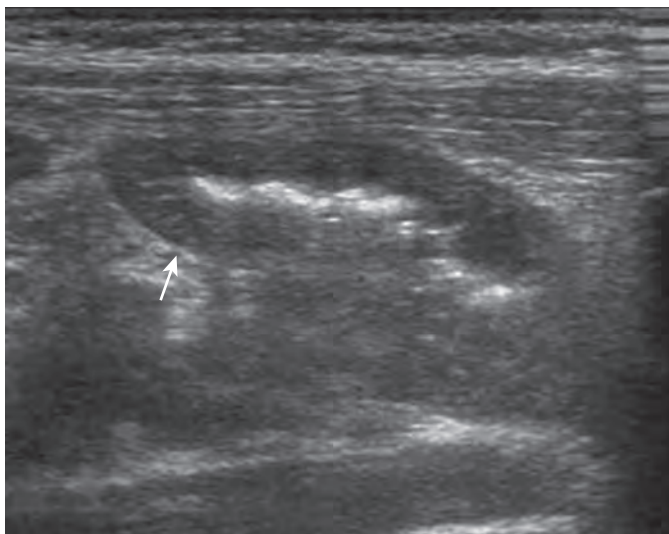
Henoch-Schönlein purpura: ultrasonography. Abnormal loop of small bowel showing marked thickening of the wall (arrow).
